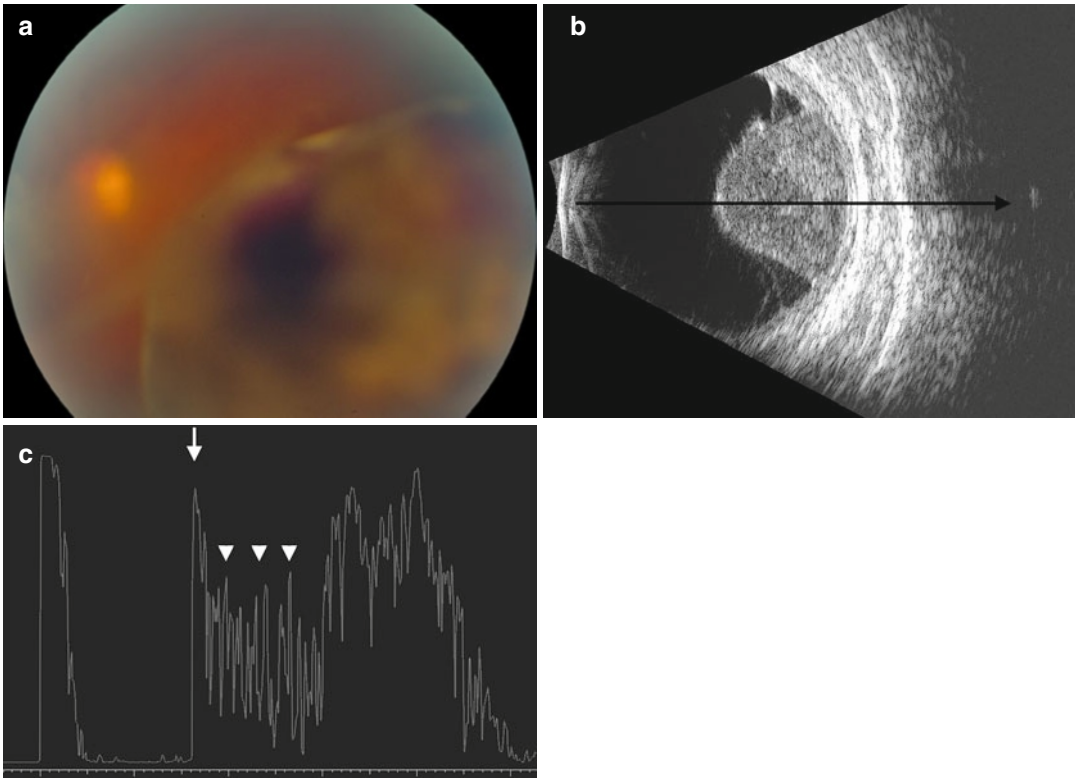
Quantitative ultrasonography (reflectivity). Fundus photo showing choroidal melanoma with vitreous hemorrhage (a). Corresponding B-scan (b). Arrow represents the path of sound beam used to generate the A-scan.
